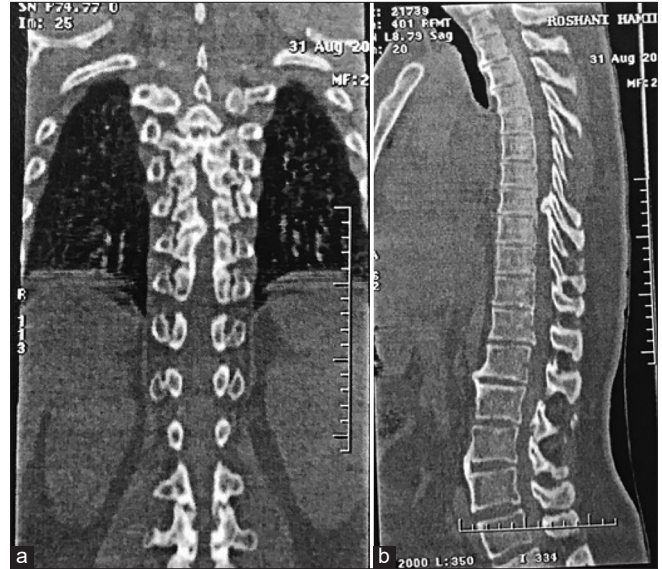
Reconstructed CT scan of thoracic spine, (a) coronal view shows a right sided T9-T10 ossification of the ligamentum flavum (OLF) and (b) sagittal view shows a beak type TOLF, note bamboo spine in thoracic (BASRI score of 4) and interrupted syndesmophytes formation in lumbar spine (BASRI score of 3).
